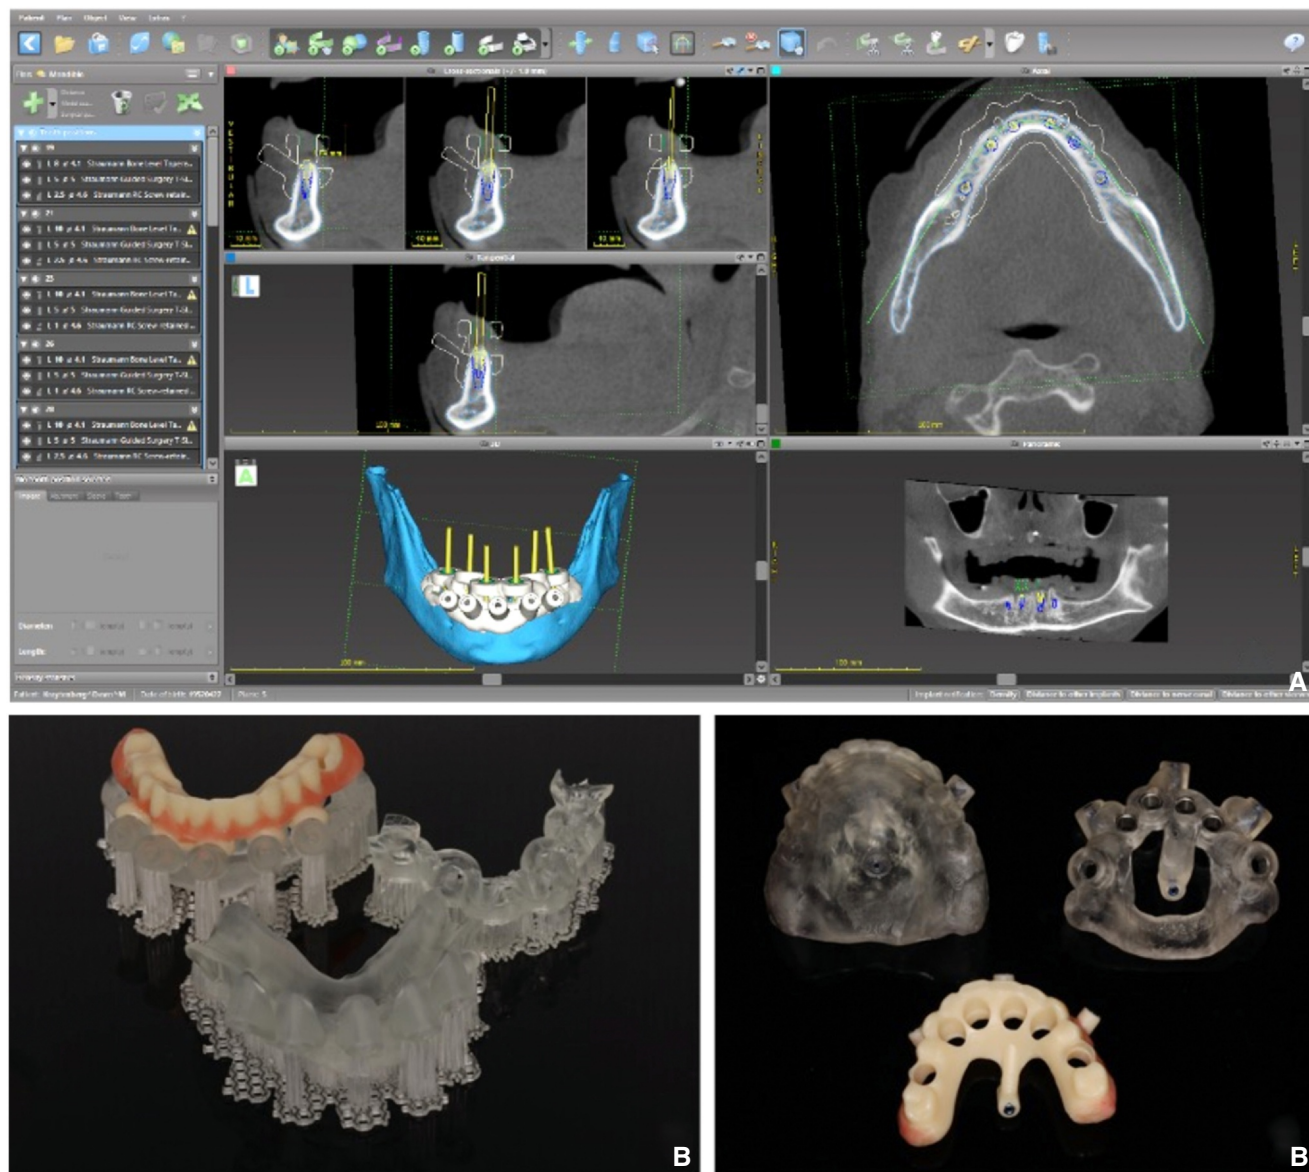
A, Implant planning using cone beam computed tomography. B, Mandibular and maxillary printed surgical guides and interim prostheses.
